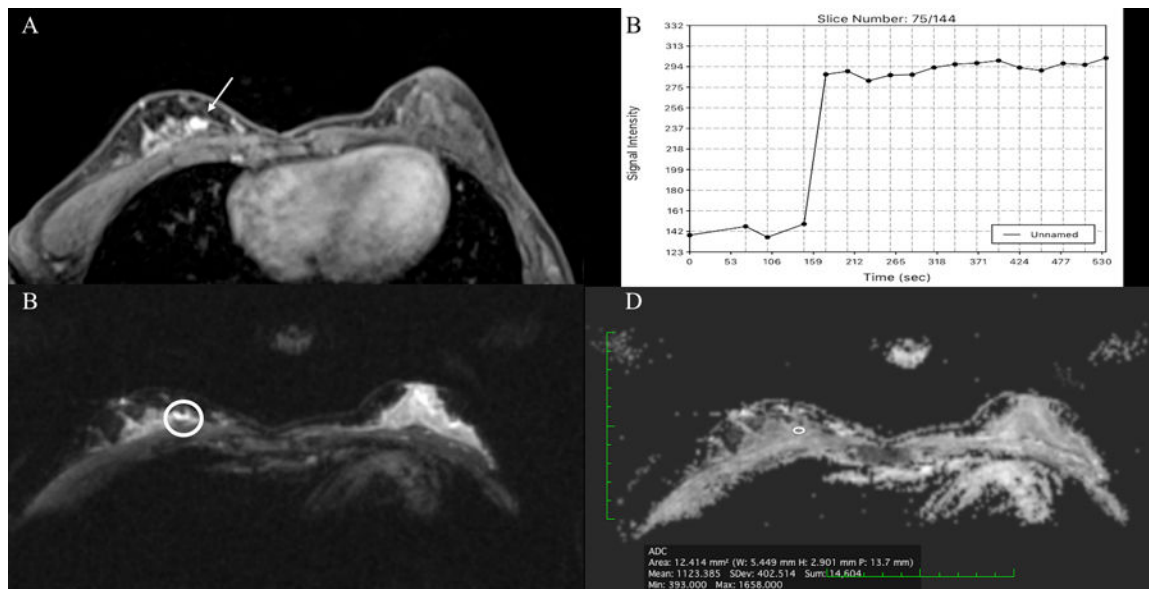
Invasive ductal carcinoma in a 41-year-old woman grade 3, medially in the right breast (arrow). In the initial independent review of DWI all readers scored negative for malignancy. (A) On DCE-MRI there is a 8mm circumscribed, oval lesion demonstrating (B) an initial fast/persistent (II) heterogeneous contrast enhancement, that was classified as probably benign (BI-RADS 3). However, when interpreted as mpMRI, reader acknowledged a (C) restricted diffusivity (circle) and (D) decreased ADC values ($1.1123 \times 10^{-3} \text{ mm}^2/\text{s}$) for the enhancing mass. mpMRI using the combined information of both DCE-MRI accurately classified this lesion as malignant.
